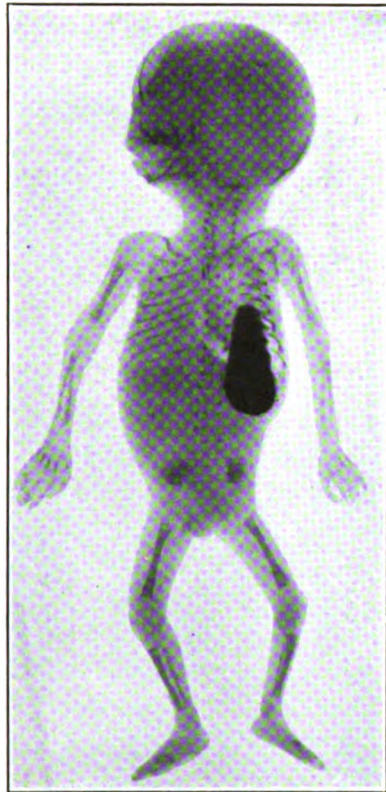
Roentgenogram showing position of stomach in a sixteen weeks' fetus.
